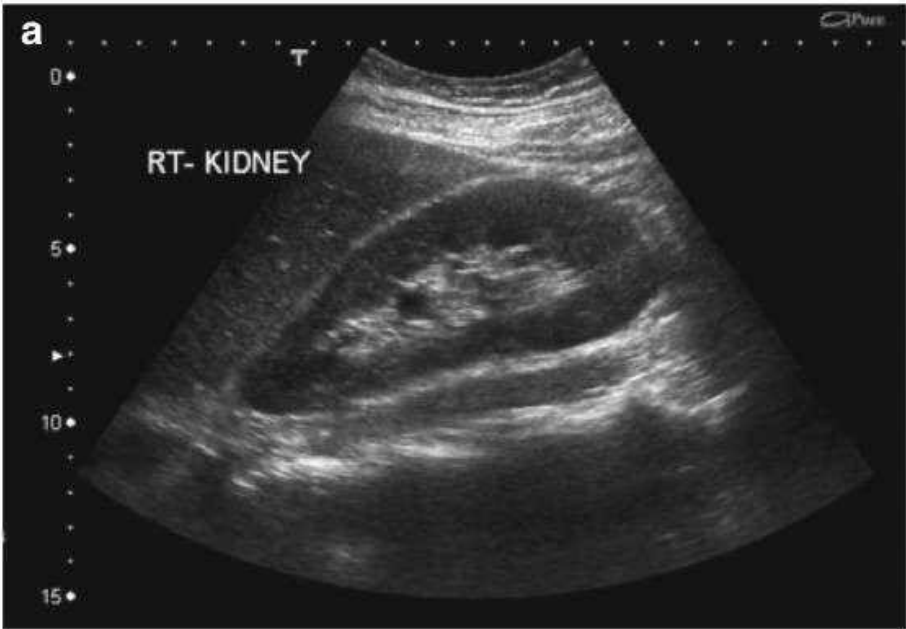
A cystic renal mass on USS and CT
